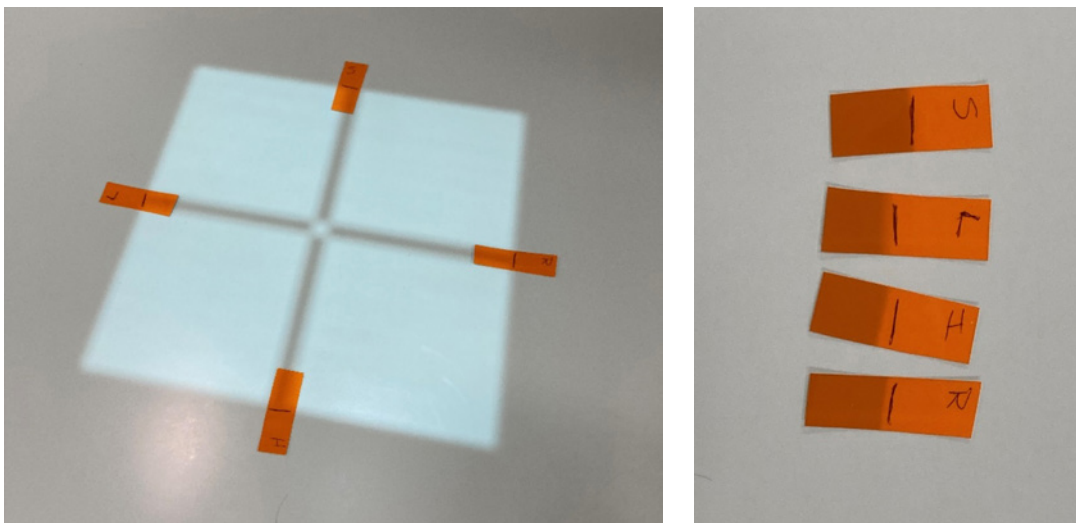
Measuring x-ray/light field alignment using radiochromic film.
